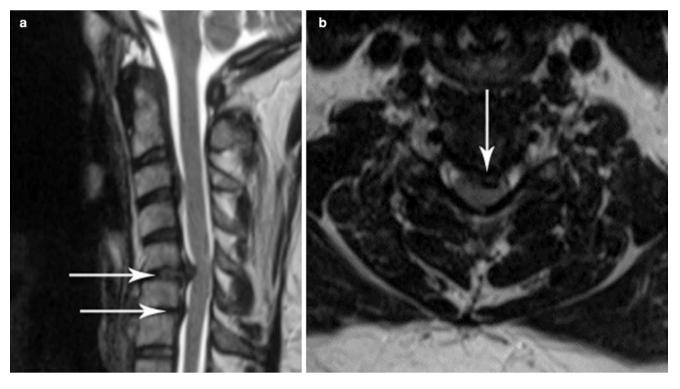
Imaging at the patient's initial presentation. Sagittal T2-weighted magnetic resonance imaging (MRI) of the cervical and thoracic spine showed a large disc herniation at C5/6 and a smaller disc herniation at
